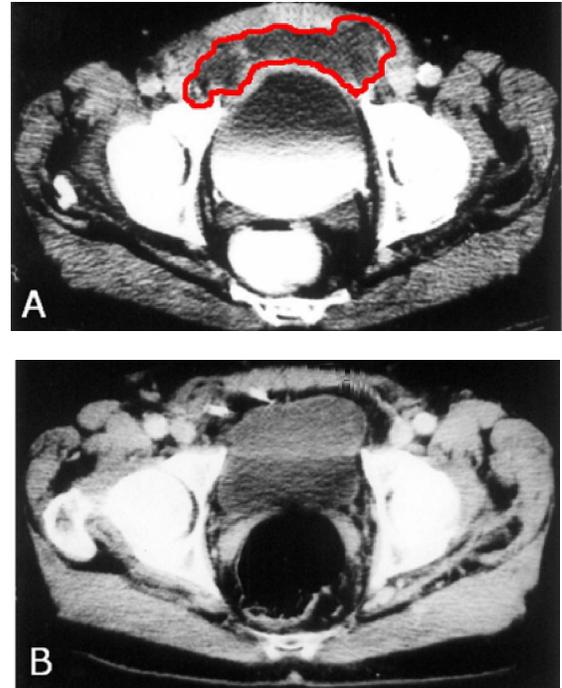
A. Ct showing collection in the pre-peritoneal space. B. CT of the same patient after proper drainage.
